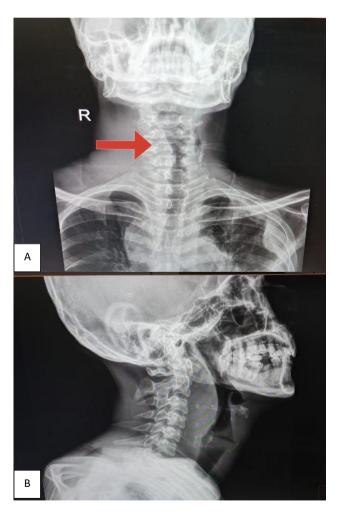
(A and B): Radiograph of neck anteroposterior and lateral showing anterior and lateral displacement of airway and widening of prevertebral shadow.
